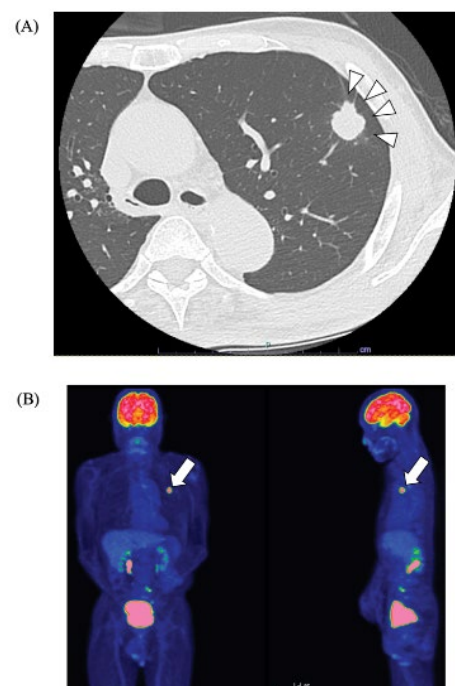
Preoperative image findings. (A) CT image revealed a 21-mm solid lung tumor with spiculation in the left upper lobe (arrow heads) and (B) PET-CT indicated FDG accumulation with an SUV of 10.9 at the tumor, without any other place of accumulation (arrowheads).
